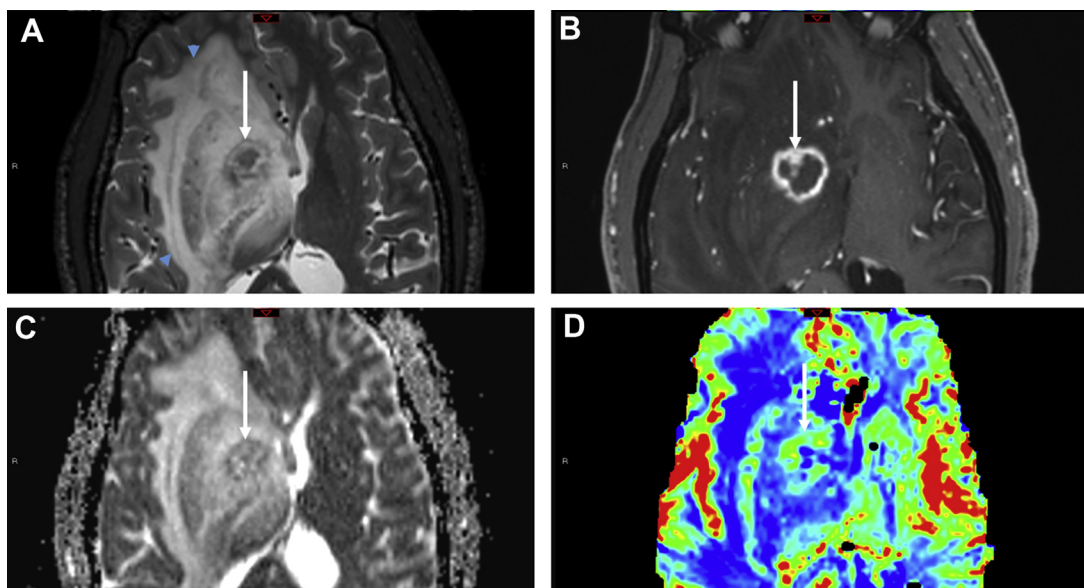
Toxoplasmosis. Axial T2-weighted (A), axial postcontrast T1-weighted (B), ADC map (C), and axial perfusion-weighted (PWI) cerebral blood volume map (D) MR images in a 47-year-old immunocompromised patient presenting with headache. Right basal ganglia lesion shows the “concentric target sign” on T2-weighted images as alternating zones of hypointensity/hyperintensity (white arrow in A) and substantial perilesional vasogenic edema (blue arrowheads in A). T1-weighted images show the “eccentric target sign” as a small nodular focus of enhancement along the lesion wall (white arrow in B). The lesion shows predominantly intralesional T2 shine through on ADC map (white arrow in C) and mild capsular hyperperfusion on PWI (white arrow in D).
